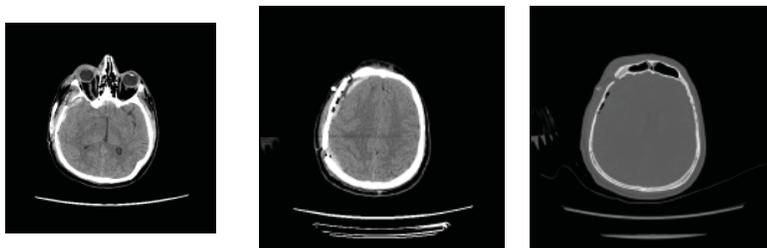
The follow up CT Brain done in the 1st post-operative day. (a) A more medially located EDH towards the superior sagittal sinus and the falx. (b) The contusion became clearer after the removal of the first hematoma with minimal pneumocephalus denoting the recent surgery. (c) The bone window is showing avulsed bone flap from the mass effect of the underlying EDH
